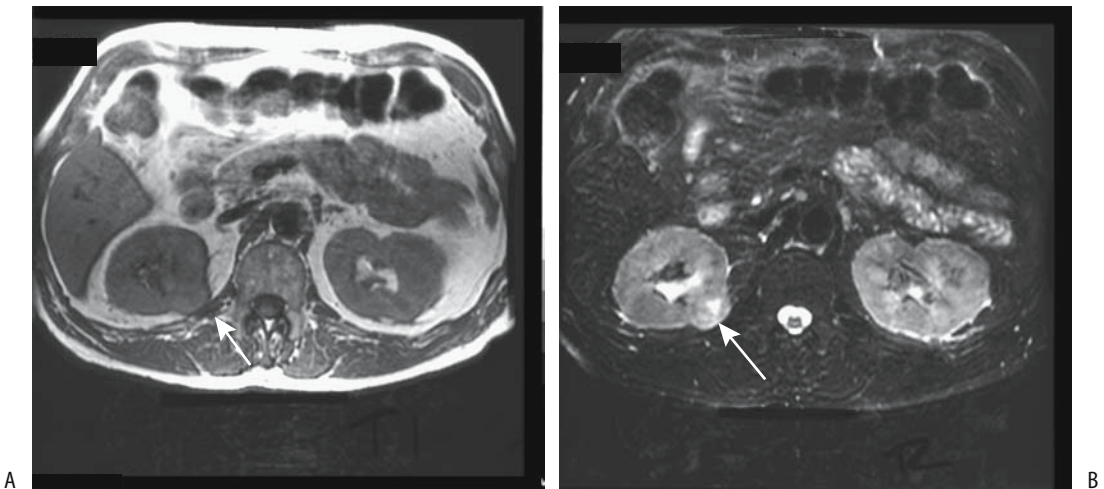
A renal adenoma (arrows) is isointense on T1- (A) and T2- (B) weighted MR images. (Source: Burgener FA, Meyers SP, Tan RK, Zaunbauer W. *Differential Diagnosis in Magnetic Resonance Imaging*. Stuttgart: Thieme, 2002, with permission.)
